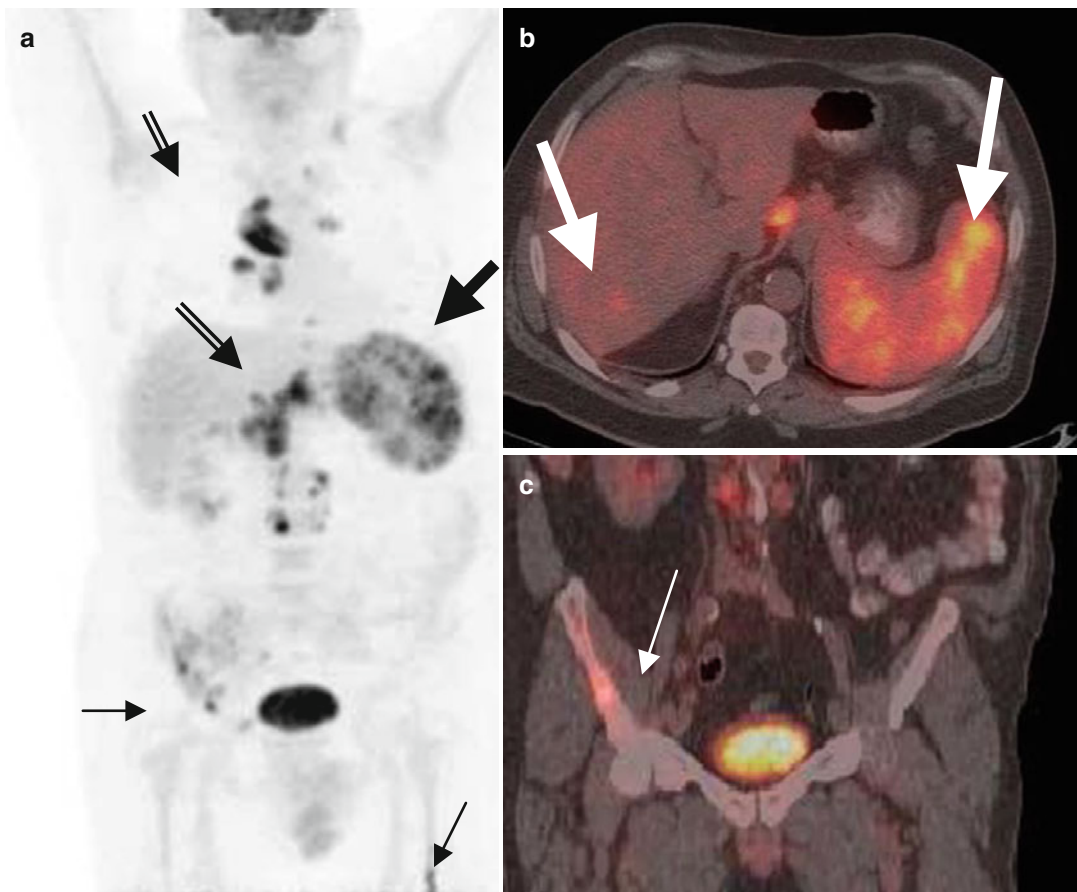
(a–c) A staging PET/CT confirmed the presence of extensive, highly hypermetabolic (SUVmax 15) lymphadenopathy both above and below the diaphragm (a – open arrows); highly increased, heterogeneous, and patchy 18-FDG uptake in the spleen as well as a focal
